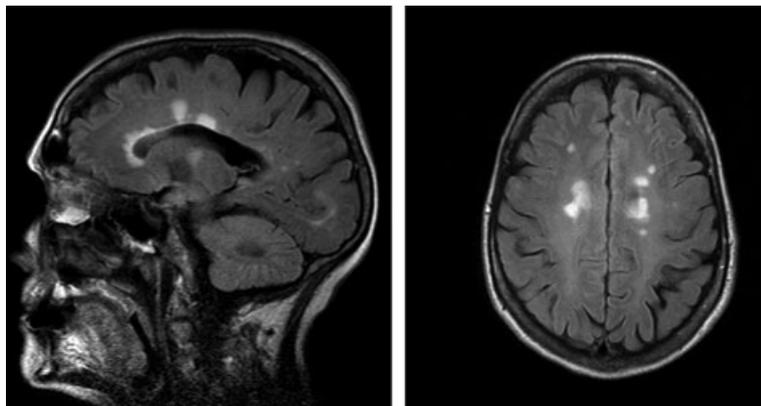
Chronically appearing callosomarginal plaques in MRI (sagittal and transversal FLAIR images) in a woman with non-progressive multiple sclerosis (MS), EDSS = 0 and normal cognitive function according to neuropsychological tests 50 years after the onset of MS.
